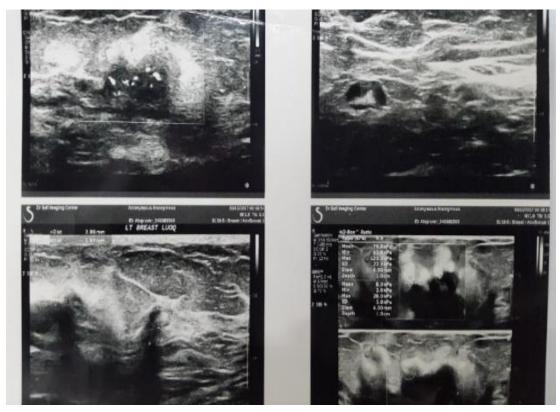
Ultrasonography revealed a large lobulated mass with highly echogenic border and posterior acoustic shadow
